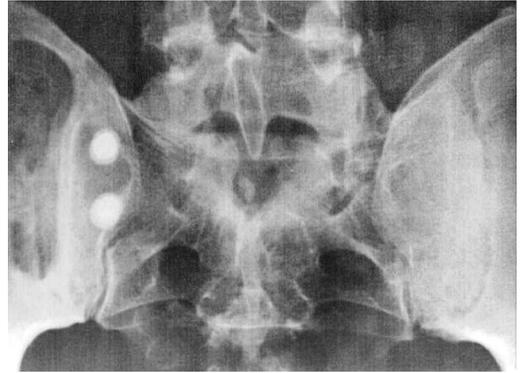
The gap model in the posterior part of the iliac crest (Study VI). The X-ray demonstrates that two implants, one hydroxyapatite- and one fluorapatite-coated are inserted.
